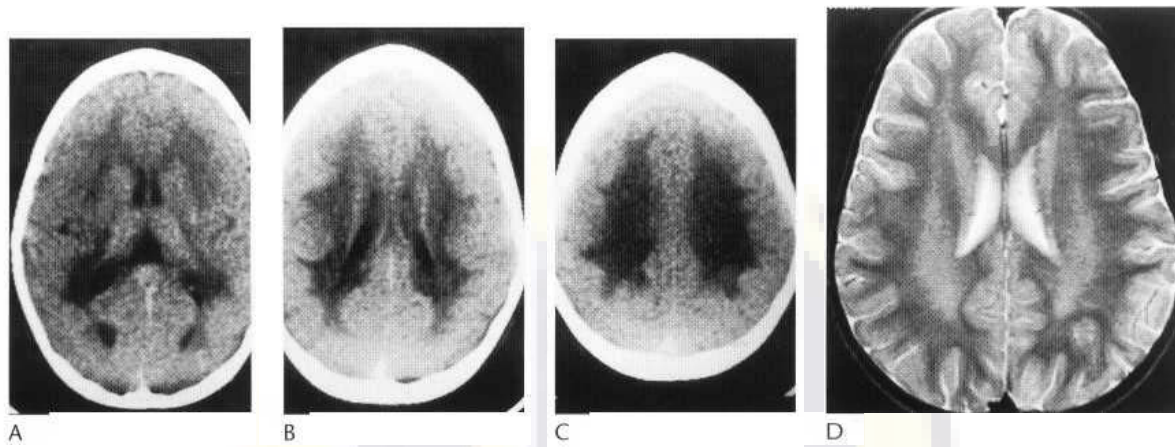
(A-C) Axial CT scans demonstrating confluent and symmetrical low-density change in the deep and peripheral supratentorial white matter in metachromatic leucodystrophy. (D) Axial MR T_2 W shows widespread low density in white matter.
